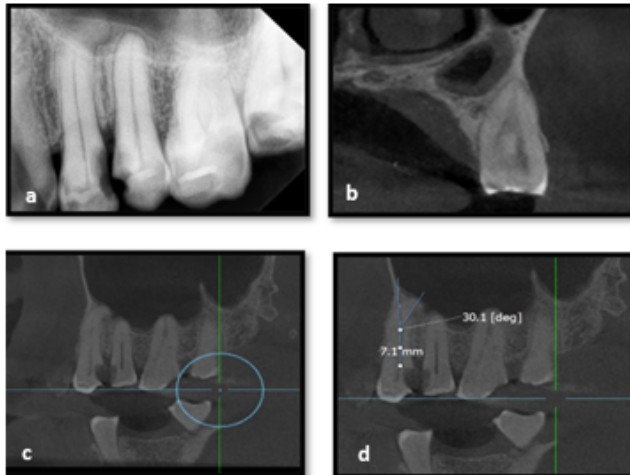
a:) Preoperative radiograph showing dilacerated root canal in relation to 24. CBCT image showing b:) Cross sectional view c:) sagittal view d:) measurement of root curvature (Schneider's method) of 24.
